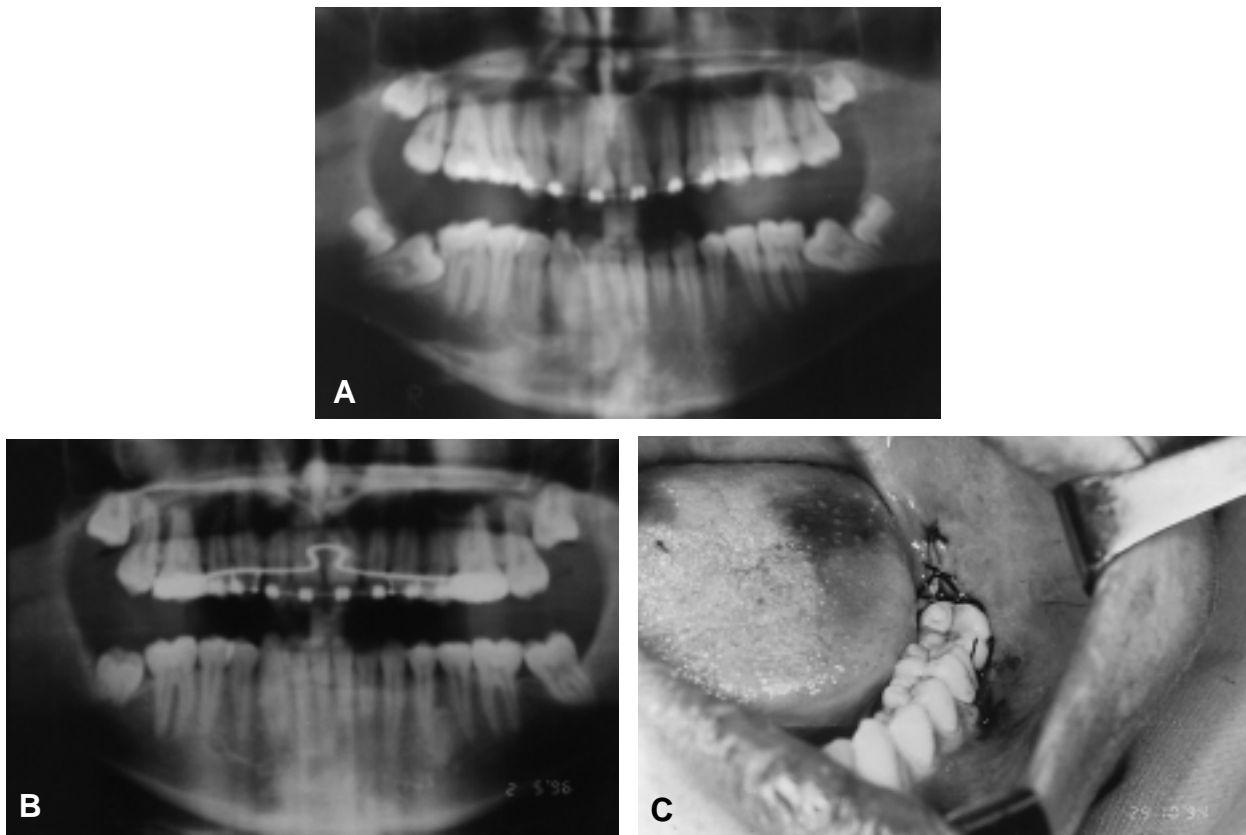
A, Panoramic radiograph of a 14-year-old boy before luxation and orthodontic traction of both lower second molars. B, Panoramic radiograph 15 months after luxation and traction of both lower molars. Left lower second molar failed to respond to treatment and shows a follicular cyst.
